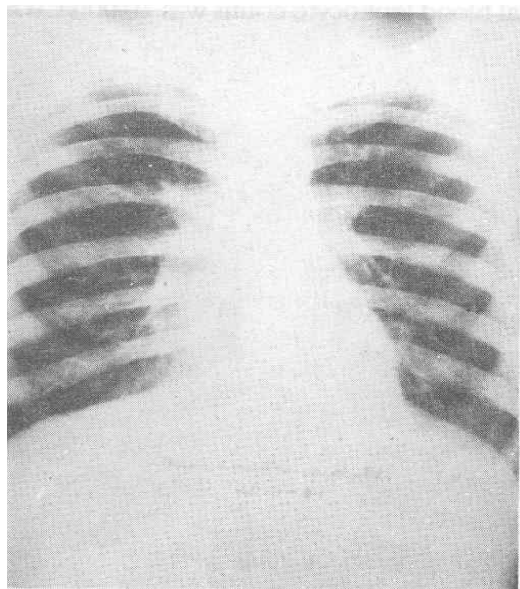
Chest radiograph showing expansion of lung after 3 weeks of Diethylcarbamazine Therapy
